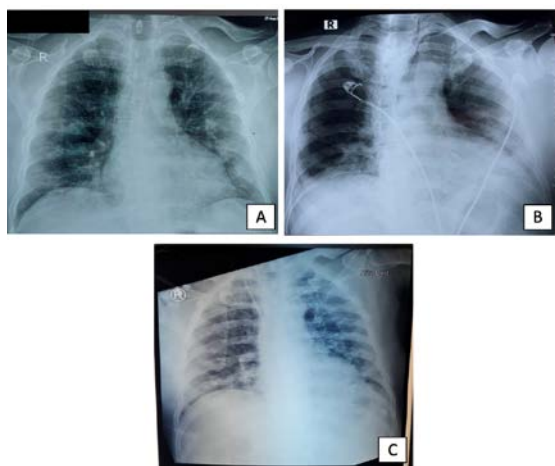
An overview of the development of chest x-ray during hospitalization from August 27, 2021 to September 3, 2021. A. Showed a bilateral pneumonia. B. Showed the improvement of patient's chest x-ray on September 2, 2021. C. Showed the worsening of patient's chest x-ray on September 3, 2021.
